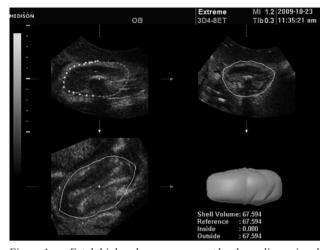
Fetal thigh volume assessment by three-dimensional ultrasonography.
